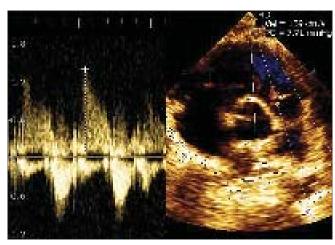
Echocardiogram of the patient showing cardiomyopathy
